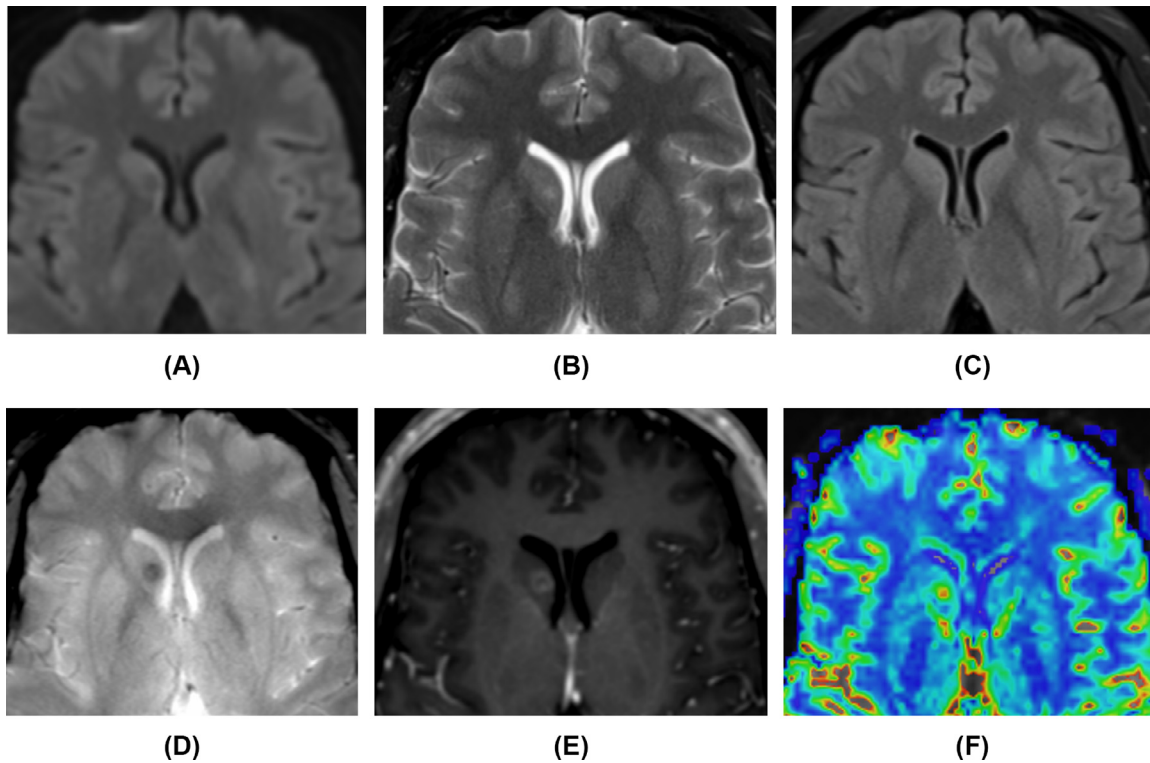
Follow-up 3.0T MRI obtained five months after initial MRI remonstrates the unchanged right caudate head lesion with (A) no restricted diffusion. The lesion remains mildly (B) T2 and (C) T2-FLAIR hyperintense without significant edema. (D) On GRE sequences there is increased blooming on 3.0T imaging relative to prior 1.5T imaging. (E) There is unchanged subtle rim-enhancement on postcontrast T1-weighted imaging. (F) The lesion demonstrated increased CBV on perfusion sequences.
